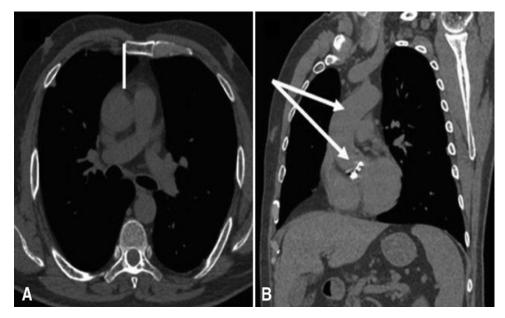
Preoperative chest computed tomography. (A) Axial plane. (B) Sagittal plane–preoperative chest computed tomography can facilitate the identification of the distance from the sternum to the right ventricle and the location of the aortic valve in relation to the sternum. These anatomic factors guide the planning and choice of surgical access in minimally invasive AVR.¹⁰
